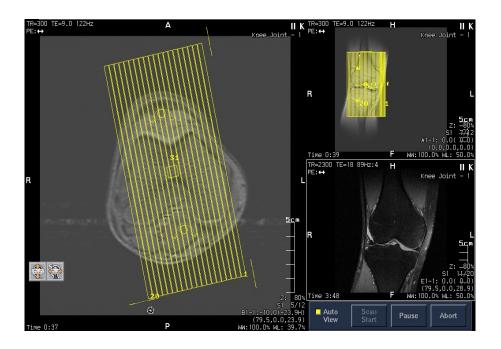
Shows MRI planning for sagittal knee joint .(Toshiba medical ,joints study : knee joint)
